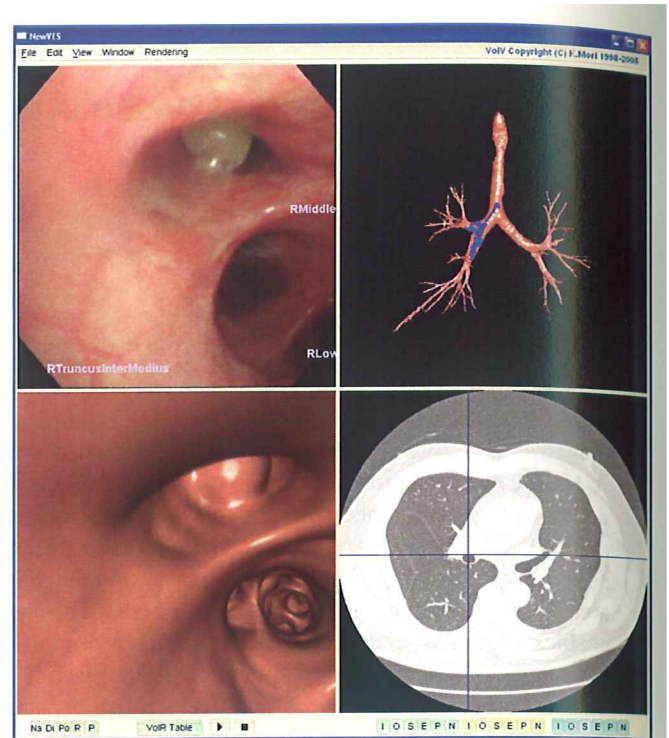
Example of the system's display. Upper-left: Real endoscopic view. Anatomical names of bronchial branches now observed are overlaid on it. Lower-left: Virtual endoscopic view that corresponds to the real endoscopic view. Upper-right: Outside view of the bronchus. The trajectory of the endoscope is shown in blue. Lower-right: CT slice at the position of endoscope.
